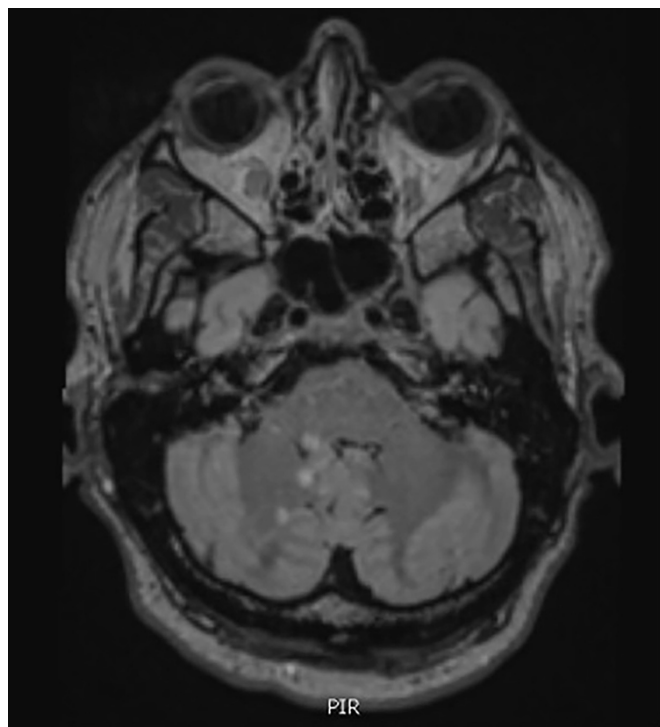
Axial image of MRI brain showing cluster of infarcts in the right posterior inferior cerebellar artery territory.
